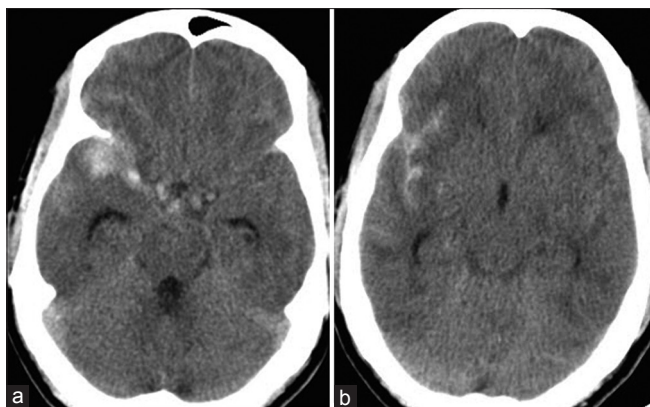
(a and b) Noncontrast computed tomography scan of the brain showing subarachnoid hemorrhage, with blood predominantly in right sylvian fissure
